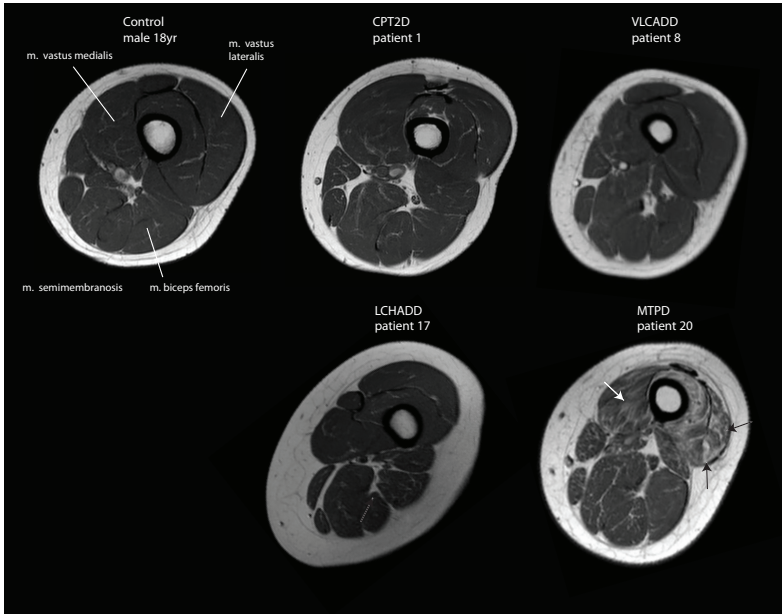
T1-weighted images of upper left leg. T1-weighted transversal images of the upper left leg in healthy control and patients with CPT2D, VLCADD, LCHADD and MTPD. Black and white arrows indicate increased signal intensity (LCHADD and MTPD).
